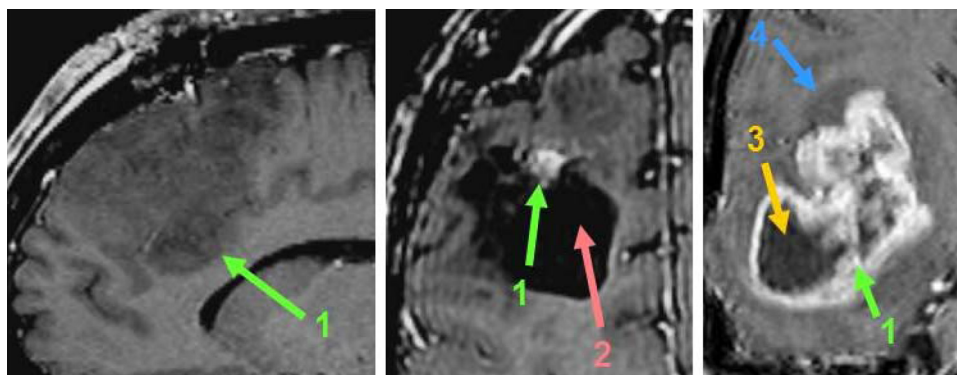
T1w MR images of gliomas. Left: grade II glioma (patient #2). Center: grade III glioma with cyst (patient #5). Right: grade IV glioma (patient #3). The colored numbers correspond to the following: (1) tumor, (2) resection cavity from previous operation, (3) necrosis, and (4) edema.
